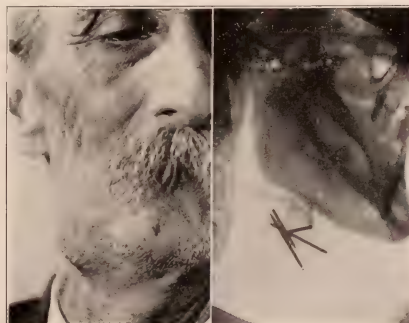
Patient had previously had cancer of the lip, with recurrence under the jaw. Heavy x-ray treatment, with fifty milligrams of radium, in four needles, imbedded for five hours. At the end of two weeks nothing could be felt. It is remarkable how rapidly these recurrences in the neck will disappear, under the combined method.
